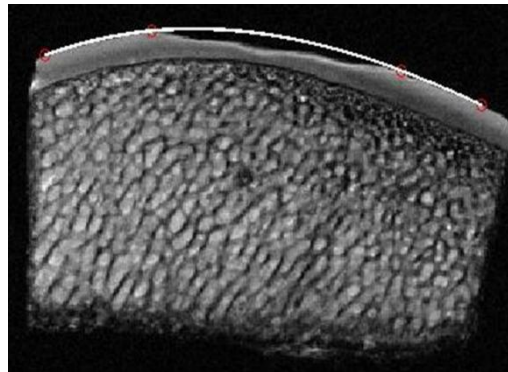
The curve fit on the MR image produced by the MATLAB™ code (Wang *et al.*, 2008).
